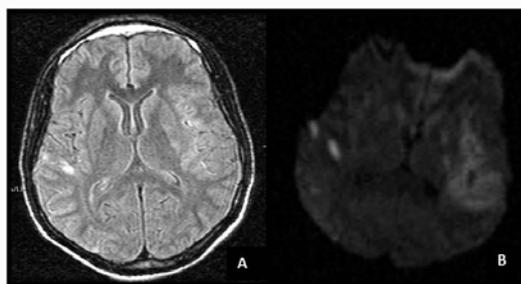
A) Focal hyperintensity on right subcortical white matter on flair sequences of DW-MRI; B) Hyperintensity on bilateral hemispheres, more prominent on the left, on T2 weighted images of DW-MRI.
